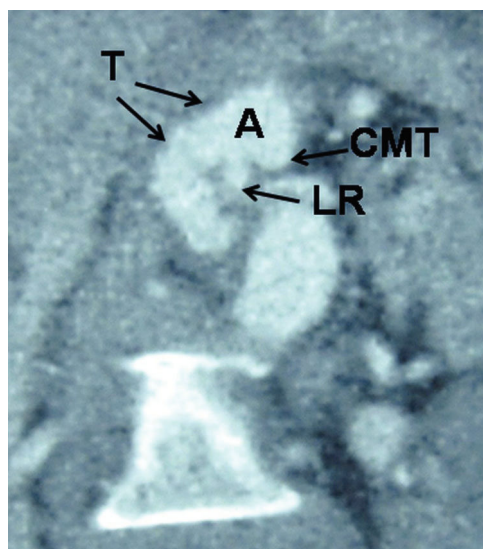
Reconstructed coronal computed tomography (CT) image. A = aorta; T = tortuosity; CMT = common celiacomesenteric trunk; LR = left renal artery.
